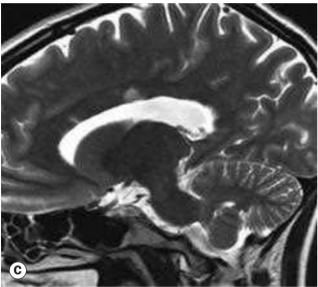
Multiple sclerosis in a patient with right-sided optic neuritis. (A) Axial T2-weighted image; (B) coronal STIR image; (C) T2-weighted STIR image showing typical hyperintense demyelinating plaques in the supratentorial white matter particularly in the corpus callosum
